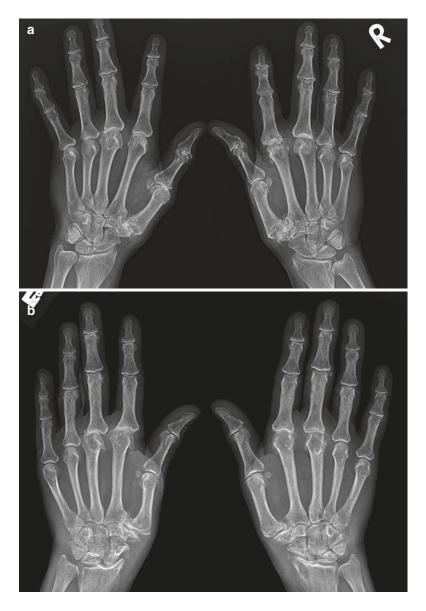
(a) A 62-year-old female with hemochromatosis, AP radiography of the bilateral hands demonstrates degenerative changes at the MCPJs, most pronounced at the second and third and the first CMC joints, subtle chondrocalcinosis of the left TFC. (b) AP radiograph bilateral hands with more advanced degenerative changes and hooklike osteophytes of the MCPJs in a 48-year-old male with hemochromatosis, also radiocarpal degeneration with scalloping radius and subchondral cyst formation, typically seen in CPPD arthropathy. (c) The same patient, AP knee radiograph with chondrocalcinosis and large medial tibiofemoral osteophytosis. (d) CT abdomen with secondary cirrhosis, liver is atrophic with surface nodularity (dashed arrow)
